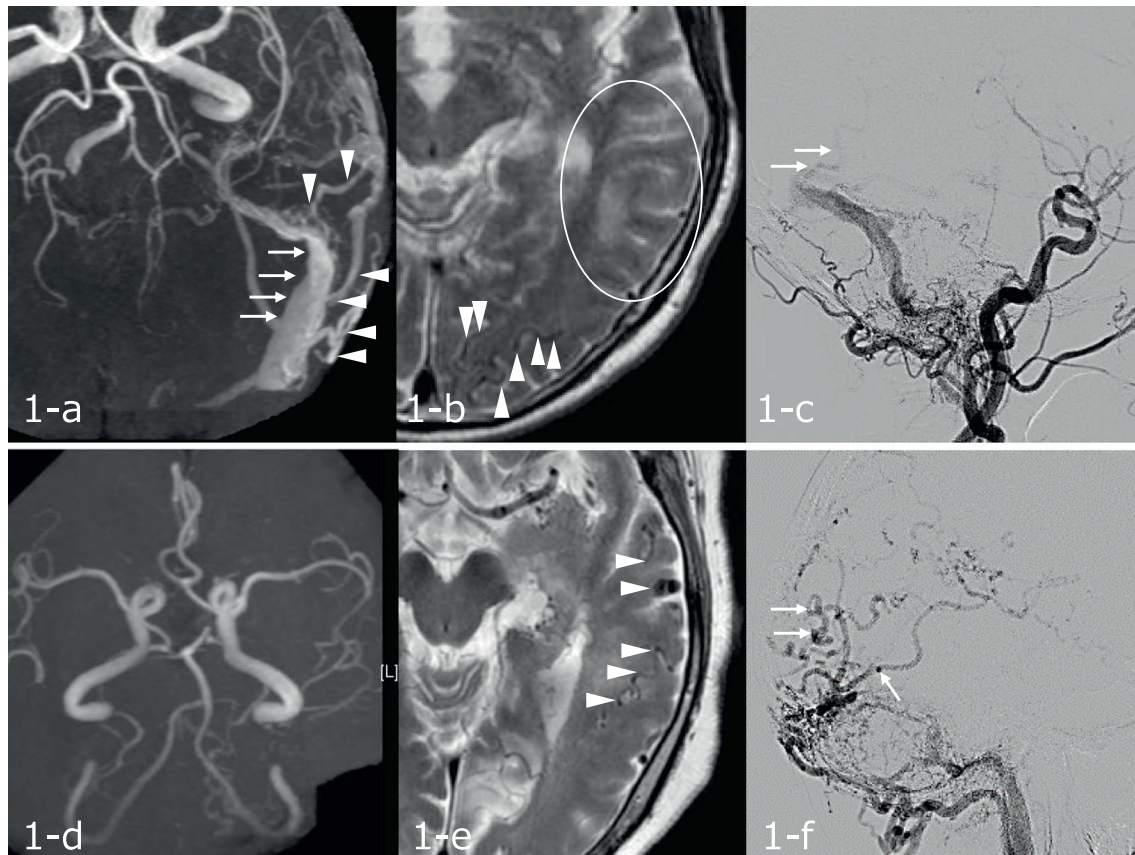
Previously reported conventional MRI findings in our patients. 1a, b, and c are from case 4; 1d and e are from case 7. 1a. MRA shows concentration of meningeal branches (white arrow heads) and abnormal flow enhancement at left transverse sinus (white arrows). 1b. T2-weighted image (T2-WI) shows abnormal flow voids (white arrow heads) and high intense lesion of white matter (white circle). 1c. Conventional digital subtraction angiography (DSA) of left common carotid artery shows cranial dural arteriovenous fistula (cDAVF) at left transverse sinus (TS) and retrograde leptomeningeal drainage (white arrows). 1d. MRA shows no abnormality. 1e. T2-WI shows abnormal flow void (white arrow head). 1f. Conventional DSA of left external carotid artery shows cDAVF at left TS, and retrograde leptomeningeal drainage (white arrows).
